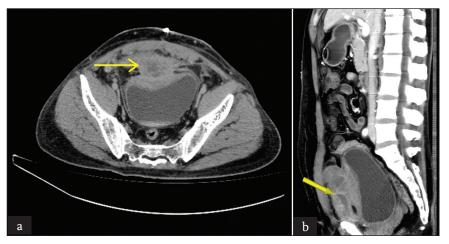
Abdominal CT scan showing (a): axial, (b): saggital, a lesion with heterogeneous solid components and thickening of anterior bladder wall (arrow)
